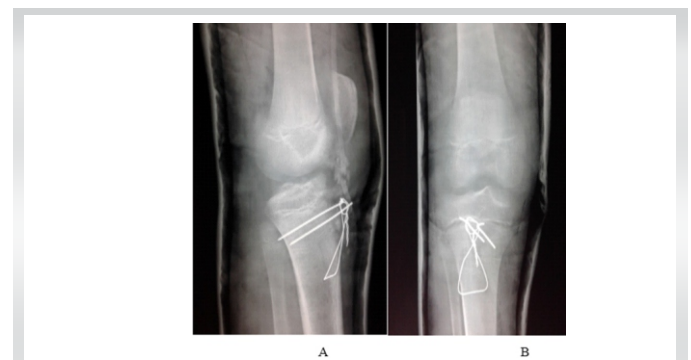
Left knee radiography post osteosynthesis by bracing (profile (B) and face (B) incidences)
